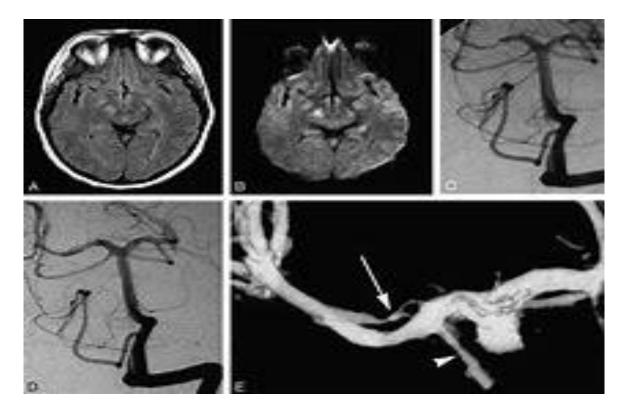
A, Axial FLAIR image demonstrating hyperintensity in the right cerebral peduncle.
